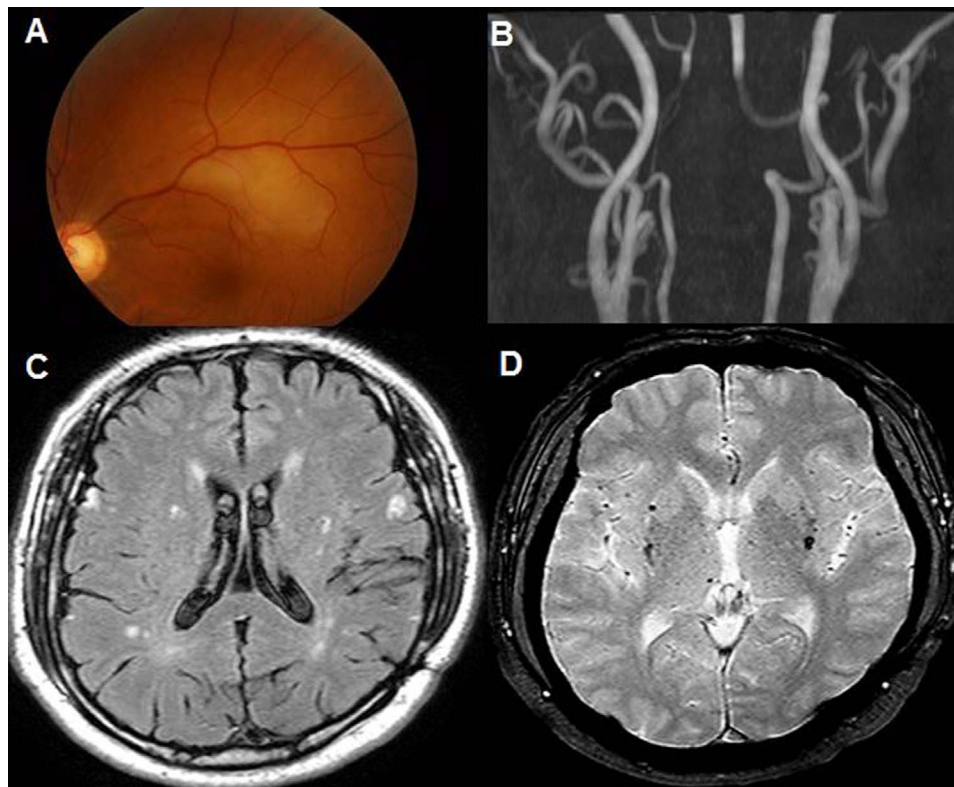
(A) A case of branch retinal artery occlusion (BRAO) without visible retinal emboli in fundus photography in an 84-year-old man. (B) Steno-occlusive lesions are not visible in intracranial and neck vessels on MRA. (C, D) White matter hyperintensities (Fazekas grade 2) on brain MRI (FLAIR image) and multiple cerebral microbleeds in both parietal lobes on T2-weighted brain MRI, corresponding to cerebral small vessel disease. MRA, magnetic resonance angiography; MRI, magnetic resonance image; FLAIR, fluid-attenuated inversion recovery.
